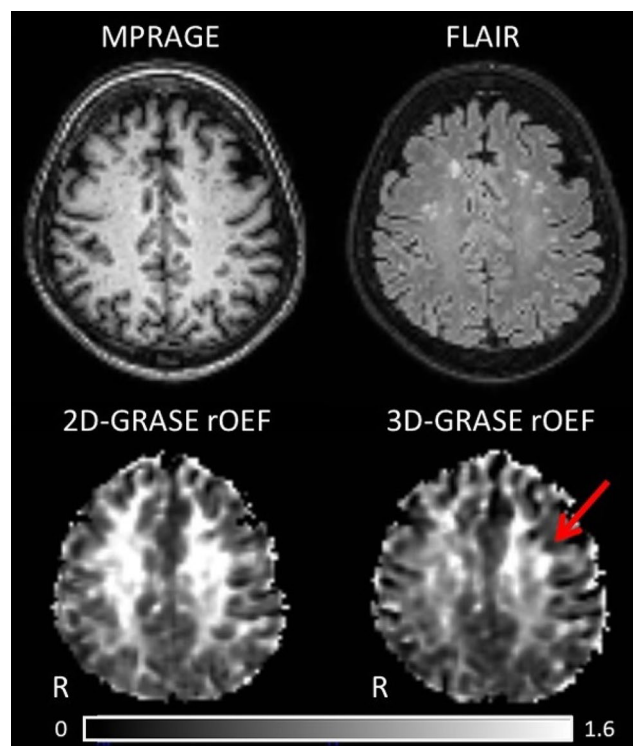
Exemplary data from a patient with left-sided ICAS. Bottom row: 2D-GrASE (left) vs. 3D-GrASE-derived rOEF maps (right) are compared along with anatomic T1w MPRAGE (top left) and FLAIR (top right) Note a focal rOEF hyperintensity ipsi lateral to the stenosis (red arrow) that is only depicted by 3D-GrASE-based rOEF
